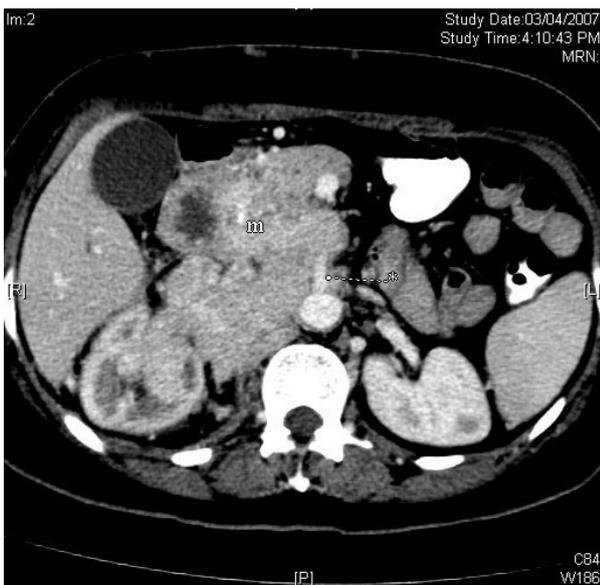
Axial post-contrast CT section showing a large mass (m) in the pancreatic head infiltrating the duodenum and encasing the superior mesenteric artery (*).
